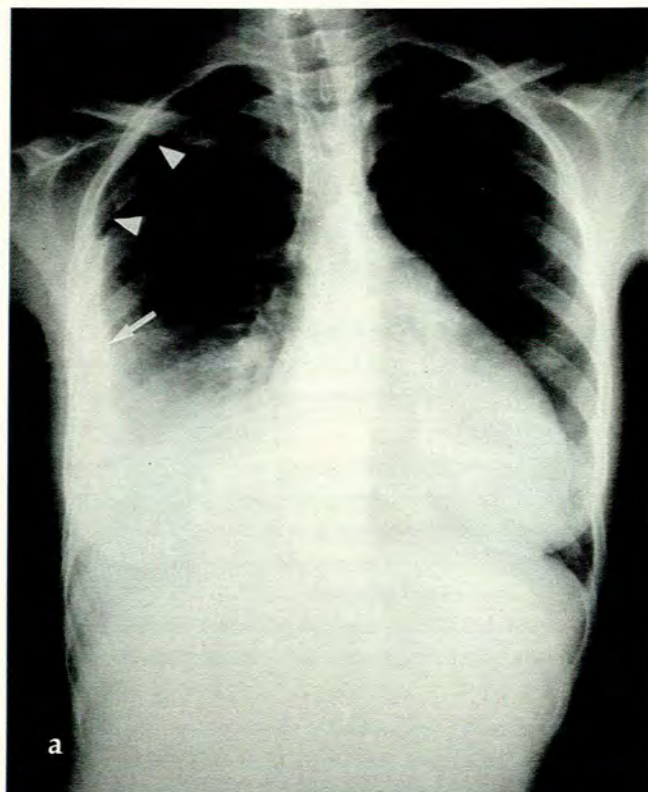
Conventional (a) and digital (b) chest radiographs of a patient with a stab wound to the chest, clearly showing right-sided pleural fluid (short arrow) and pneumothorax (arrowheads).
